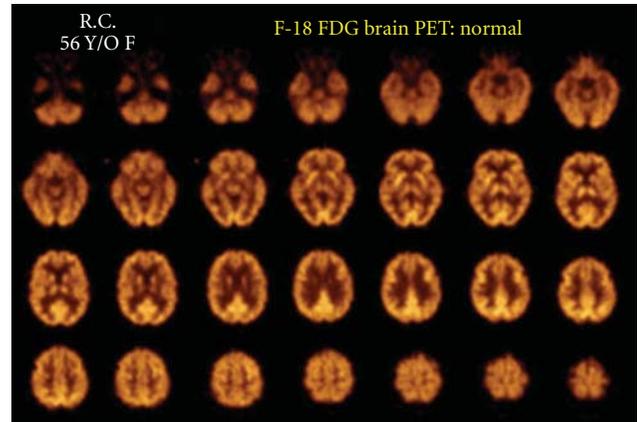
Normal F-18 FDG PET image from a 56-year-old female subject at rest. PET scan image slice thickness of ~ 4 mm reconstructed in plane image resolution = 5 mm FWHM.
